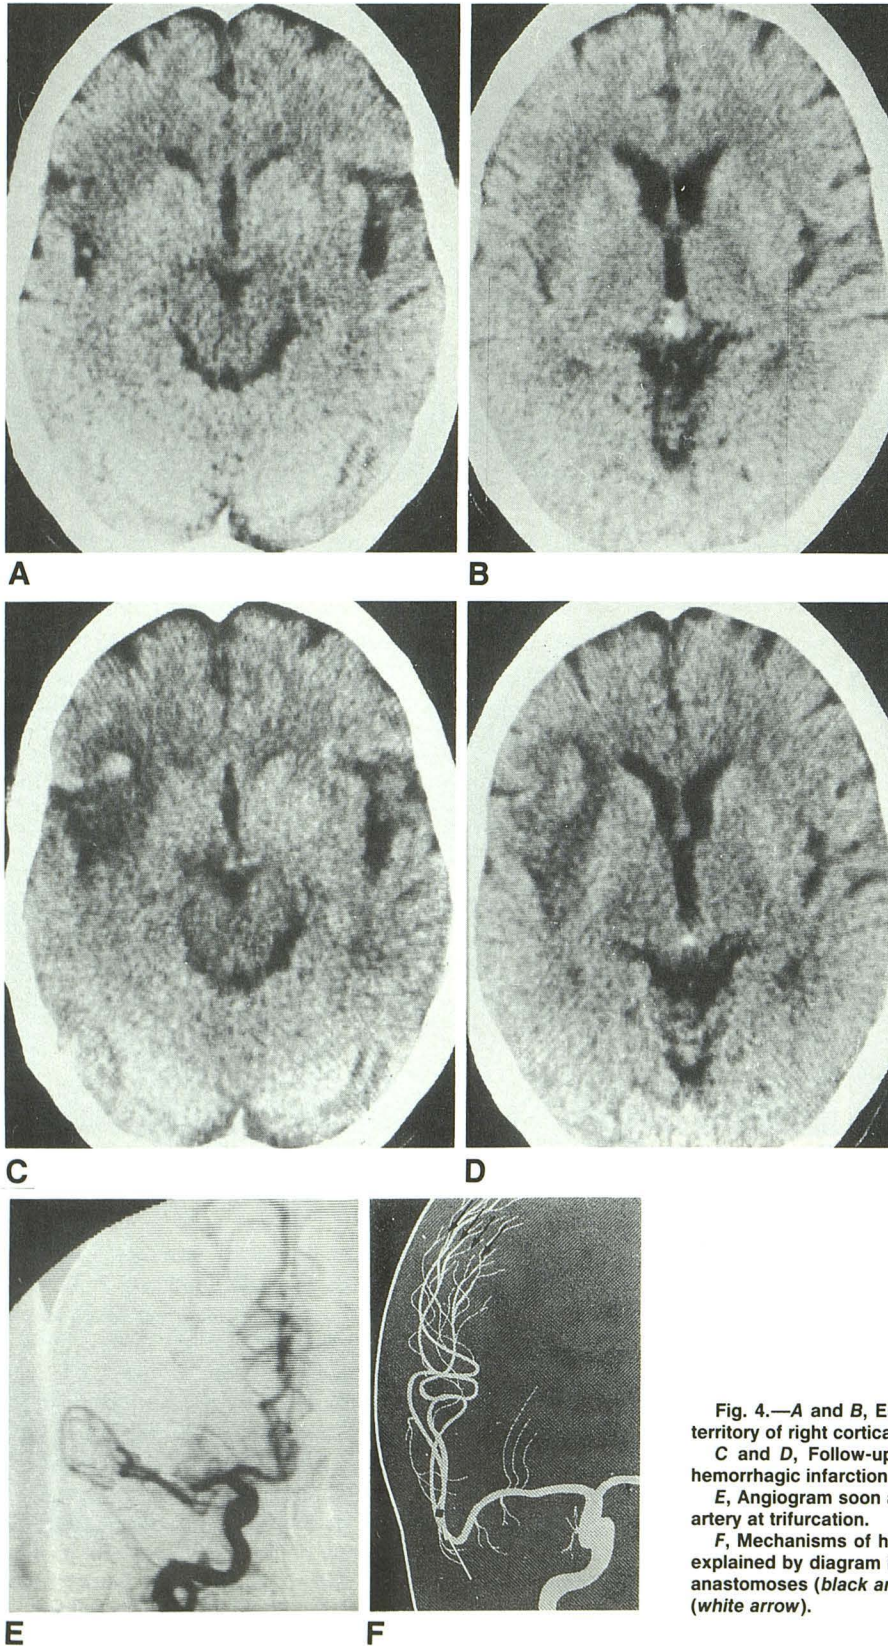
A and B, Early CT study shows hypodensity circumscribed in territory of right cortical middle cerebral artery.
